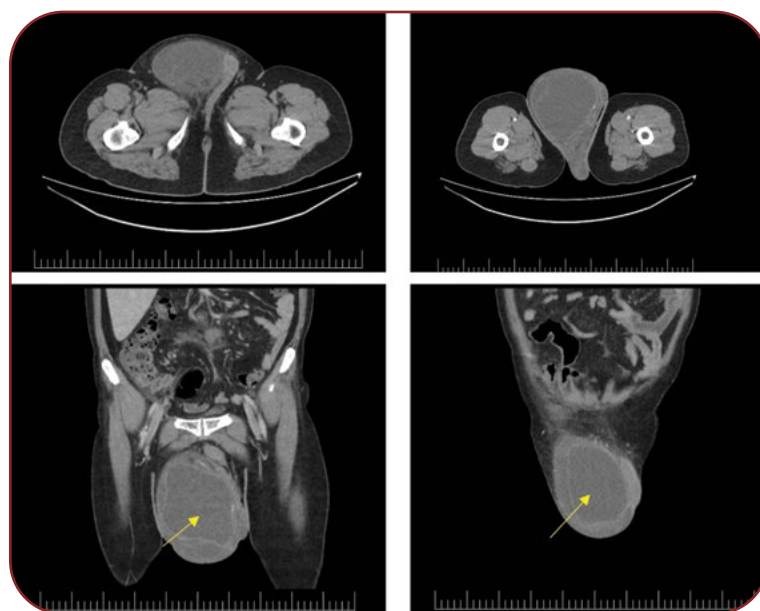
Computed tomography scan of the scrotal seroma occurred after TEP hernia repair (yellow arrow points to seroma)
